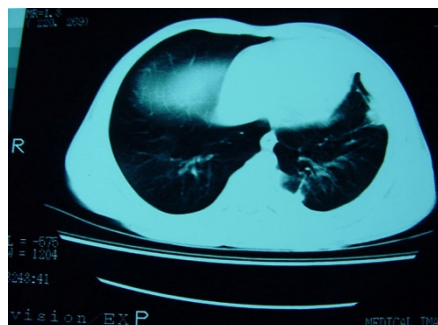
Lung CT scan showing increased pleural thickening
